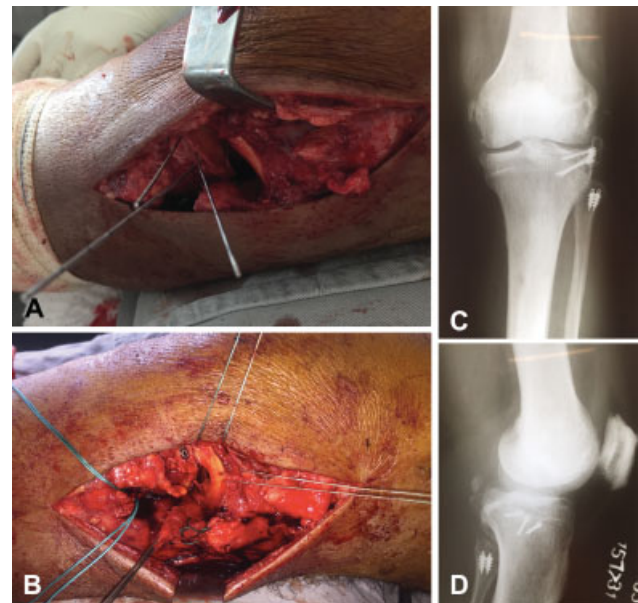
(A) Fixation of the osteochondral fragment with Hebert screws. (B) Repair of the lateral meniscus, of the lateral collateral ligament, and of the femoral biceps tendon. (C and D) Postoperative AP and profile radiographs.
